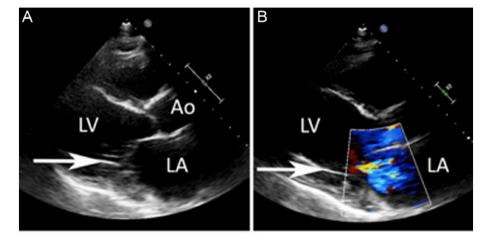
(1) Transthoracic echocardiogram 2 days following Parachute device implantation. (A) The parasternal long axis view with the tines of the Parachute device impinging upon the posterior mitral valve leaflet (white arrow). (B) A resultant moderate centrally directed jet of mitral regurgitation.
